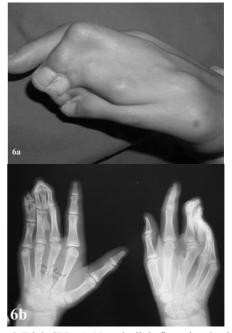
Triple SPD. a). Note the little finger involved in the synpolydactylized mass. b). Anteroposterior radiographs.
